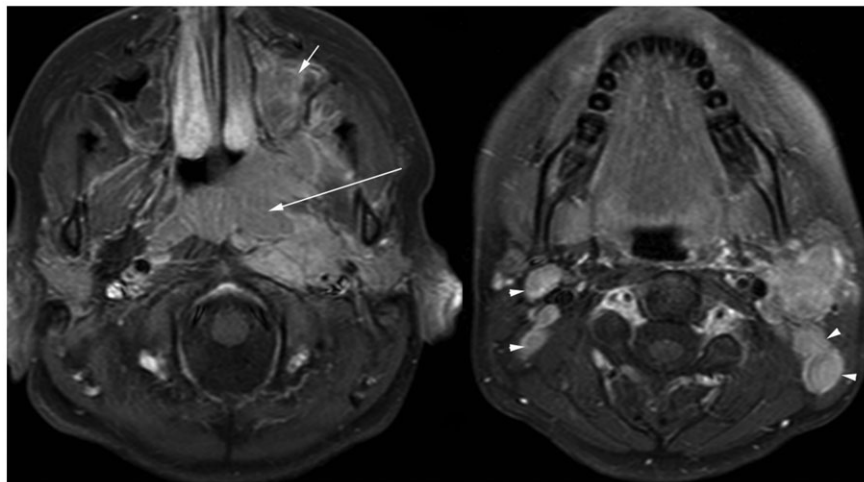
Axial contrast-enhanced fat-saturated T1-weighted MRI (TR 567, TE 12 ms) of a patient with nasopharyngeal carcinoma (long arrow) invading the left parapharyngeal space, parotid and left maxillary antrum (short arrow), with multiple lymph node metastases (arrow heads).
